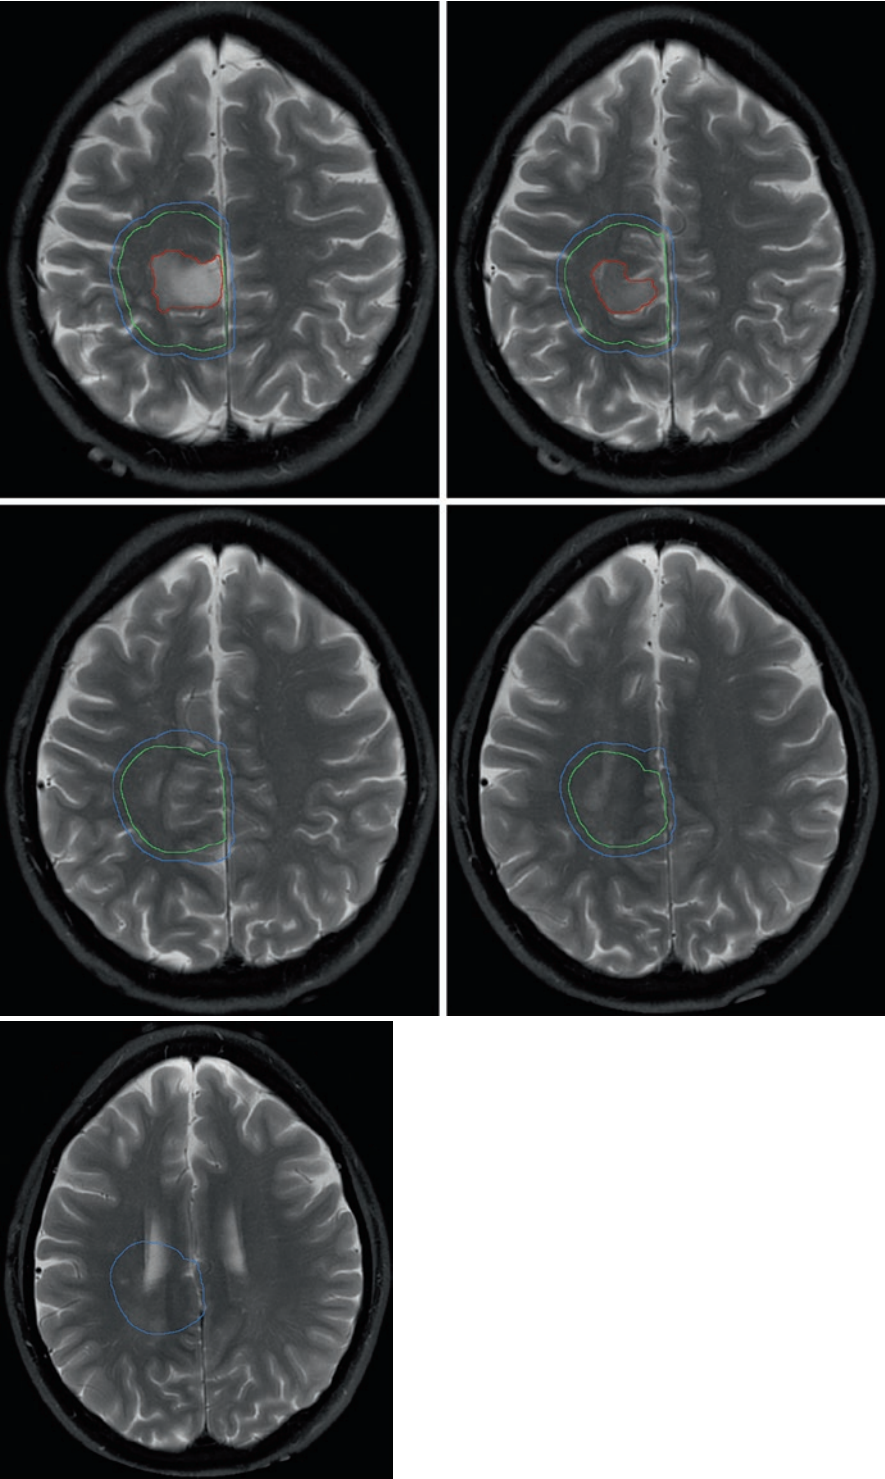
Low-grade glioma case. Axial T2-weighted MRI slices of the head of a patient with a low-grade glioma of the right frontal lobe following incomplete surgical resection. Red = GTV which encompasses both the surgical cavity and residual T2 signal abnormality. Green = CTV (GTV + 1 cm margin). Blue = PTV (CTV + 3 mm)
